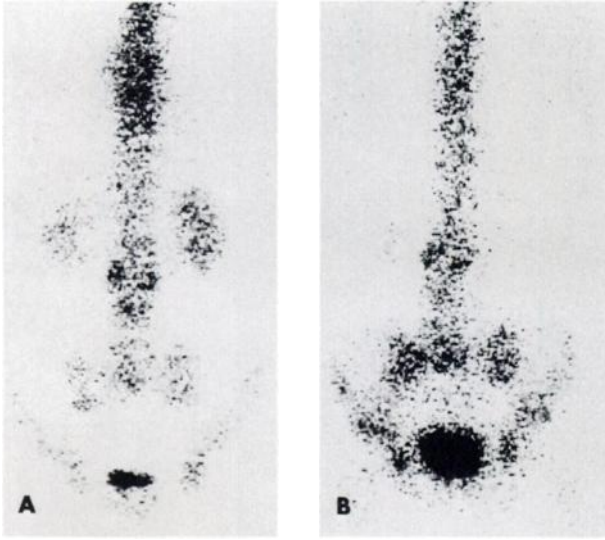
Scintigrams in 29-year-old man. Osseous uptake pattern is identical for Tc-PP (A) and ^{18}F (B). Recurrence of excised fibrosarcoma is located posterior to left kidney, in paravertebral muscles. Invasion of third lumbar vertebra is seen on both scintigrams.
